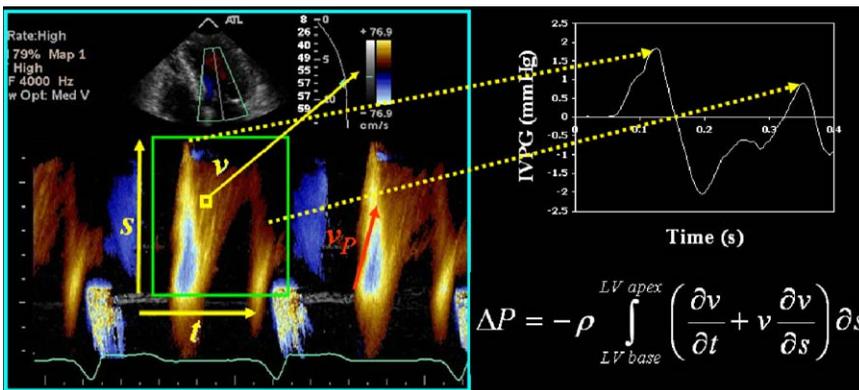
Color M-mode Doppler assessment of left ventricular filling.  $v_p$  represents the slope of the early filling propagation wavefront, measured from the tip of the mitral leaflets to 4 cm distally toward the apex at the first aliasing velocity transition (red–blue). The IVPG (top right) are determined from computational analysis of velocity ( $v$ ), space ( $s$ ) and time ( $t$ ) using Euler’s hydrodynamic equation (bottom right). The first positive component corresponds to early diastolic suction. Solid arrows indicate spatial and temporal coordinates. Velocity ( $v$ ) information is obtained from color table. Dashed arrows point to calculated peak IVPGs during early filling and atrial contraction.
